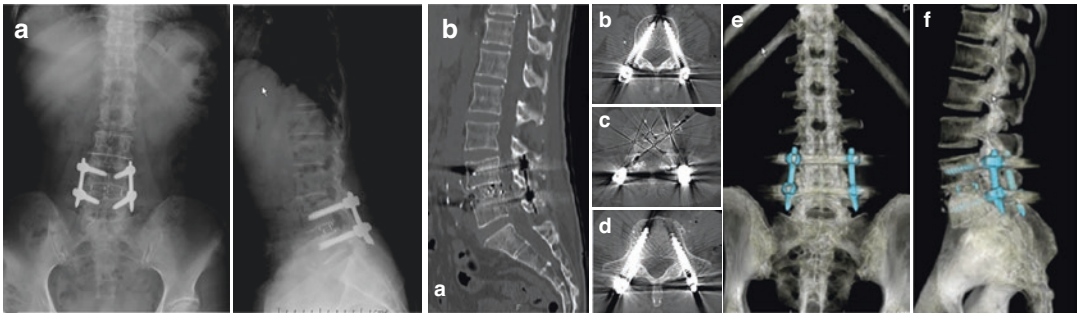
(a) Post-operative radiograph of the same patient after surgery showing implant in situ (b) O-arm images taken intraoperatively showing proper position of the screws and cage
